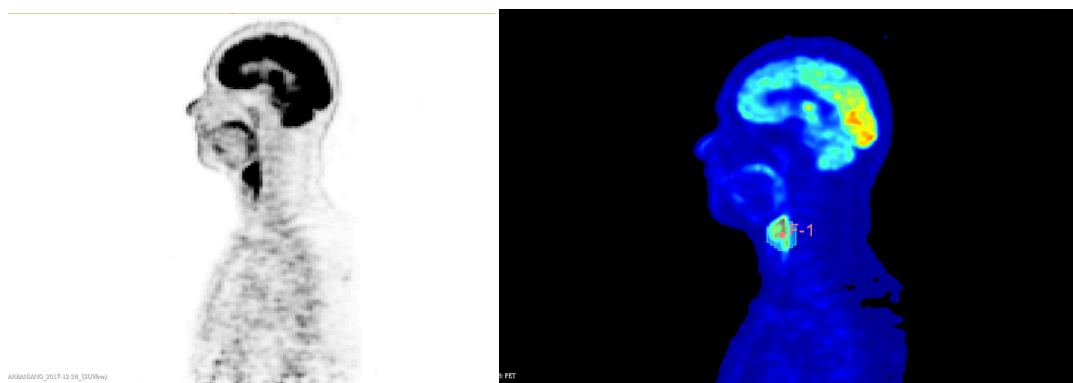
Initial segmentation to identify are with maximum SUV uptake
